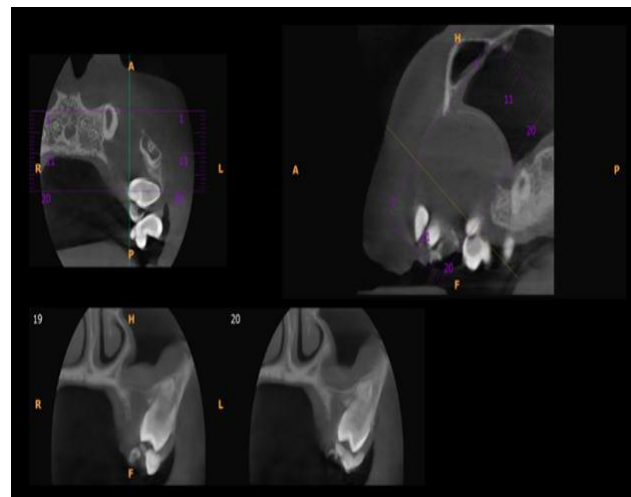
CBCT coronal view demonstrating expansile osteolytic lesion with sinus involvement.
